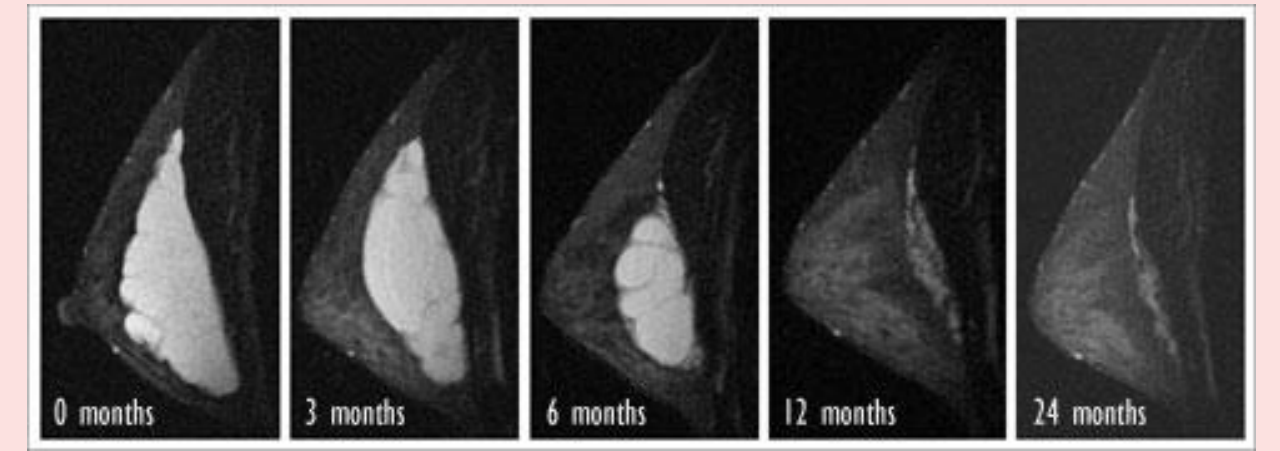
MRI shows normal degradation over 24 months
